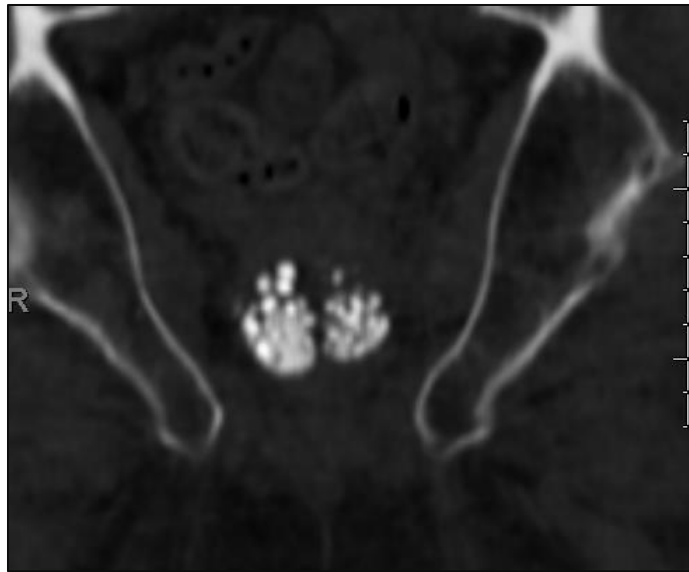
Coronal CT scan of the left hip joint of 74-year-old male (2 mm slices) in bone window demonstrate multiple rounded calcifications (calculi) in the prostate gland.
